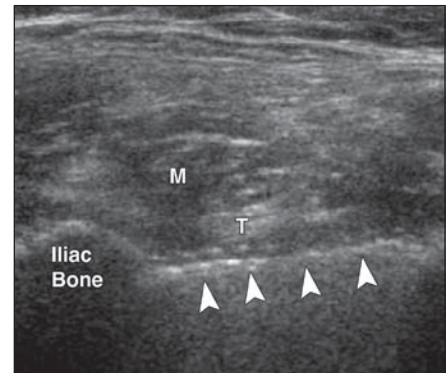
29-year-old woman with severe, unrelenting stabbing pain in right hip. Her pain became significantly worse after osteotomy surgery 2 years previously for hip dysplasia. Numerous imaging studies, including MRI, were unrevealing. Musculoskeletal sonography was not available in her region, so she flew from Portland, OR, to Philadelphia, PA, to be examined. Her orthopedic surgeon provided a prescription for sonography but told me, “You won’t find anything; that patient is crazy.” Axial sonogram at level of iliopsoas muscle (M) shows surgical screw (*arrowheads*) that has pierced iliac bone and lies deep in relation to iliopsoas tendon (T). Dynamic images (not shown) showed that whenever patient flexed her hip, tendon rubbed against the screw, reproducing her excruciating pain. Screw was surgically removed (by a different orthopedic surgeon), and her stabbing pain immediately resolved.
